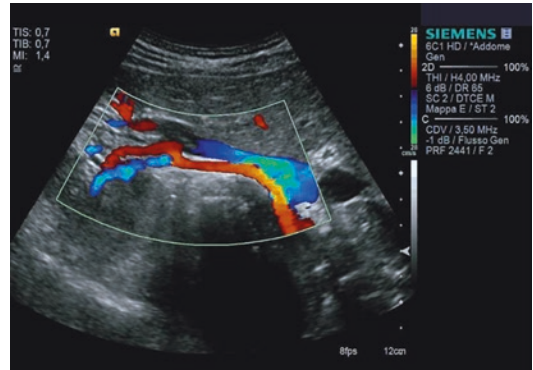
The right renal artery in subcostal view. A transverse anterior abdominal approach with the patient in lateral decubitus can help in recognizing of the renal artery behind the corresponding vein. RA flow is in the parallel direction to the Doppler beam
